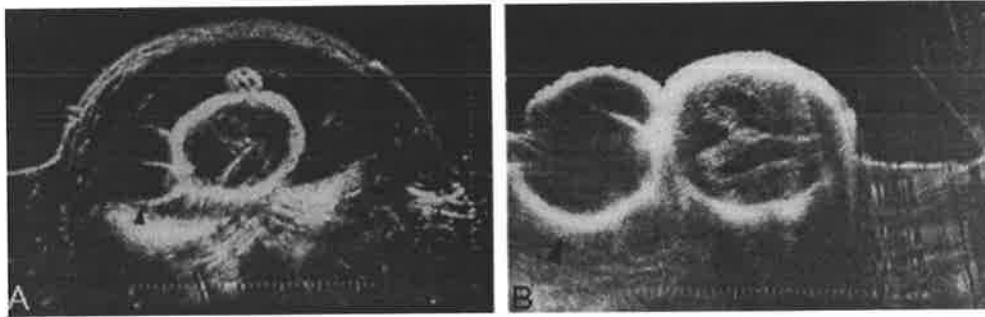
Ultrasonic scans of an occipital meningocele (arrowheads) associated with a Dandy-Walker anomaly: A antenatal (28 weeks of gestation); B postnatal.
